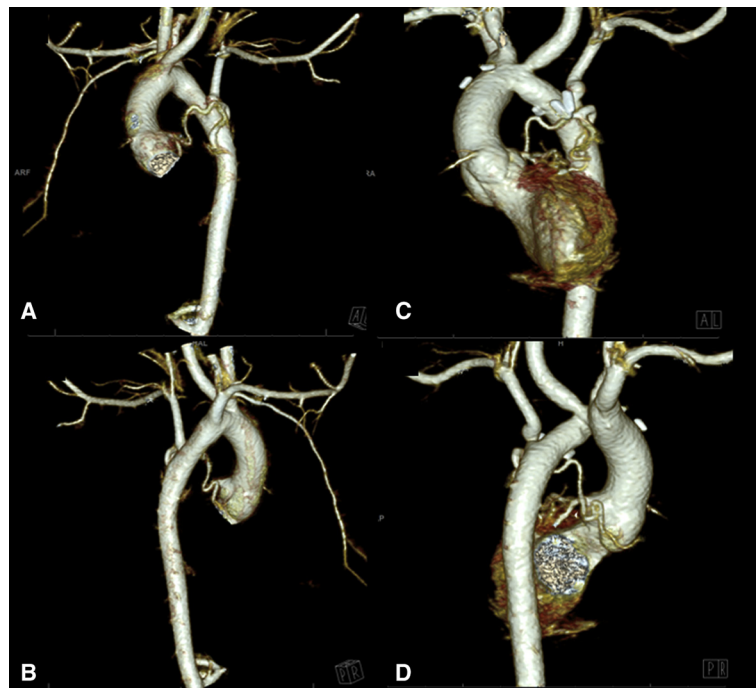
A through D, Computed tomography scan with 3-dimensional reconstruction, front and back views, comparing the circumflex aorta before (A and B) and after (C and D) the uncrossing.
